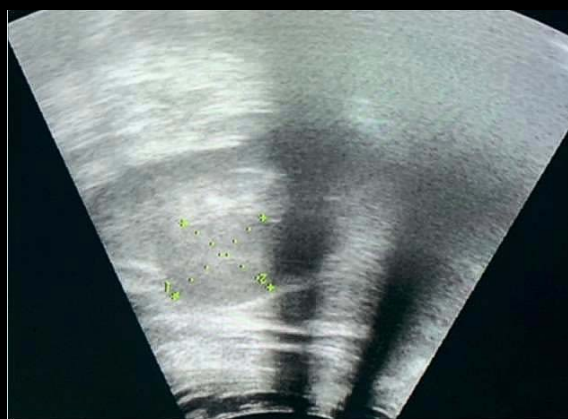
Renal ultrasound- left kidney showing heterogeneous irregular hypo- and hyperechoic formation at the inferior pole with a diameter of 46/39 mm suggestive of a tumoral formation
